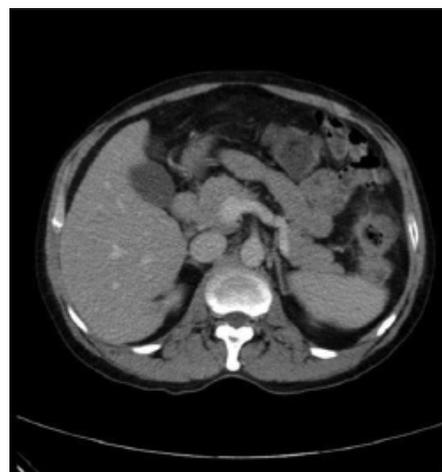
Axial contrast-enhanced computed tomography showing heterogeneously enhancing asymmetric wall thickening involving the descending colon with infiltration of the spleen suggestive of T4 stage
